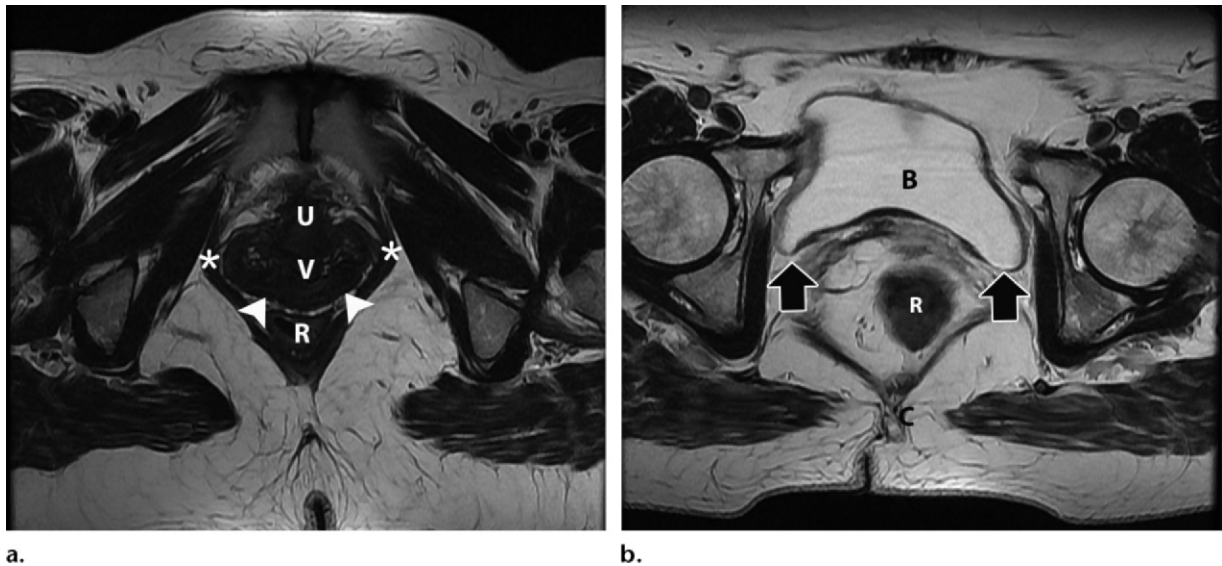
Indirect signs of paravaginal fascial tear. (a) Axial T2-weighted MR image shows loss of the normal H- or butterfly-like shape of the vagina (*V*) with deformation of the posterior vaginal wall (arrowheads) and thinning of the puborectalis muscles (*). (b) Axial T2-weighted MR image shows bilateral sagging (arrows) of the posterior wall of the bladder (*B*). *C* = coccyx, *R* = rectum, *U* = urethra.
